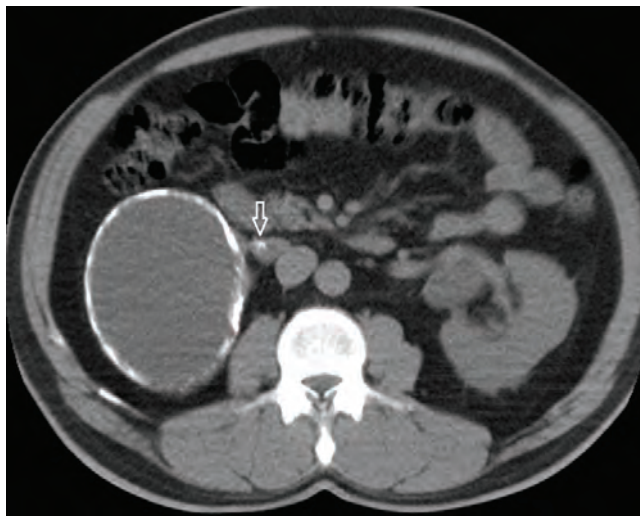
Axial unenhanced CT image shows nonspecific calcification containing soft tissue density located between the cystic mass and inferior vena cava (arrow).
